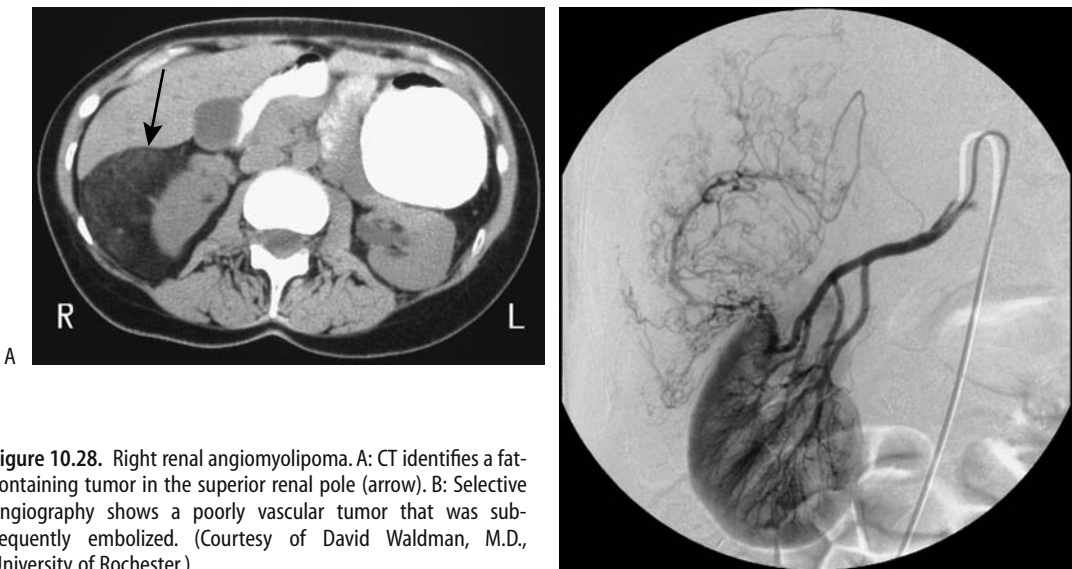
Right renal angiomyolipoma. A: CT identifies a fat-containing tumor in the superior renal pole (arrow). B: Selective angiography shows a poorly vascular tumor that was subsequently embolized. (Courtesy of David Waldman, M.D., University of Rochester.)
